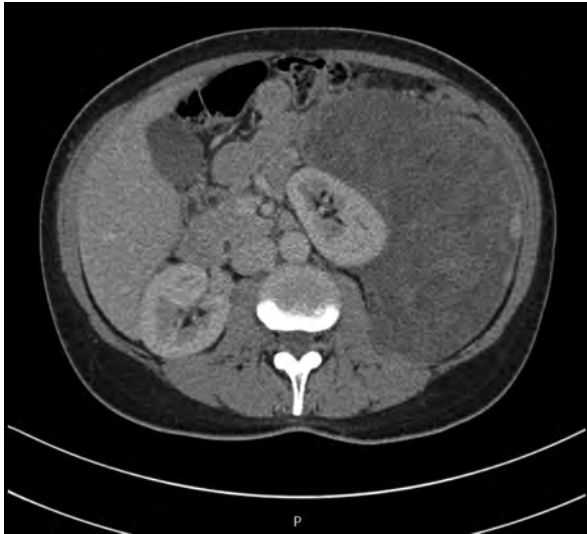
Image of the CT scan of an extensive left retroperitoneal liposarcoma that relocates the kidney
